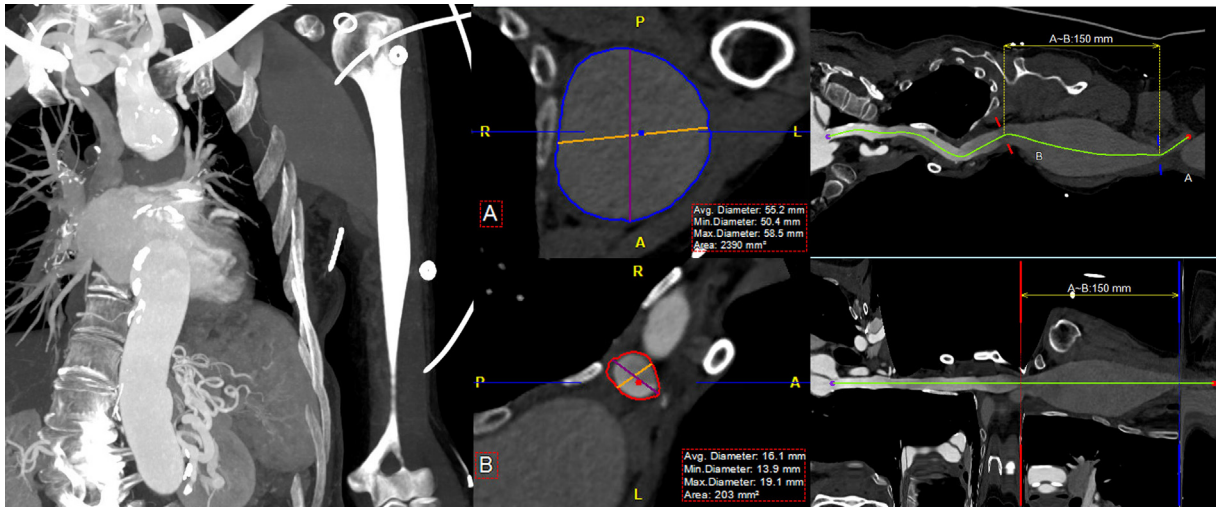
Computed tomography angiogram showing a large, 5.8-cm left subclavian and axillary artery aneurysm and patent left internal mammary artery (LIMA) graft.
